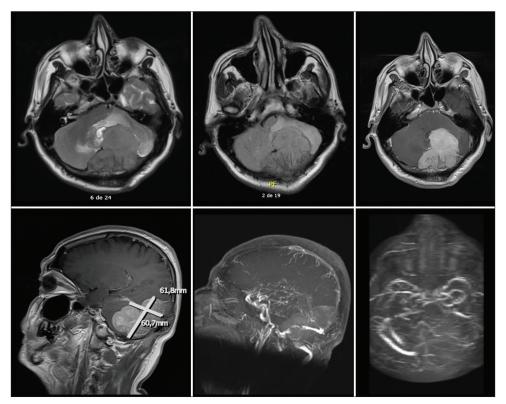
T1-weighted contrast-enhanced brain MRI, where skull invasion to the posterior fossa, the squamous portion of the occipital bone and both parietal bones can be appreciated. The fourth ventricle is displaced to the right and partially obliterated; there is also significant compression of the cerebellar left hemisphere, as well as obliteration of the right transverse sinus on the magnetic resonance angiography.
